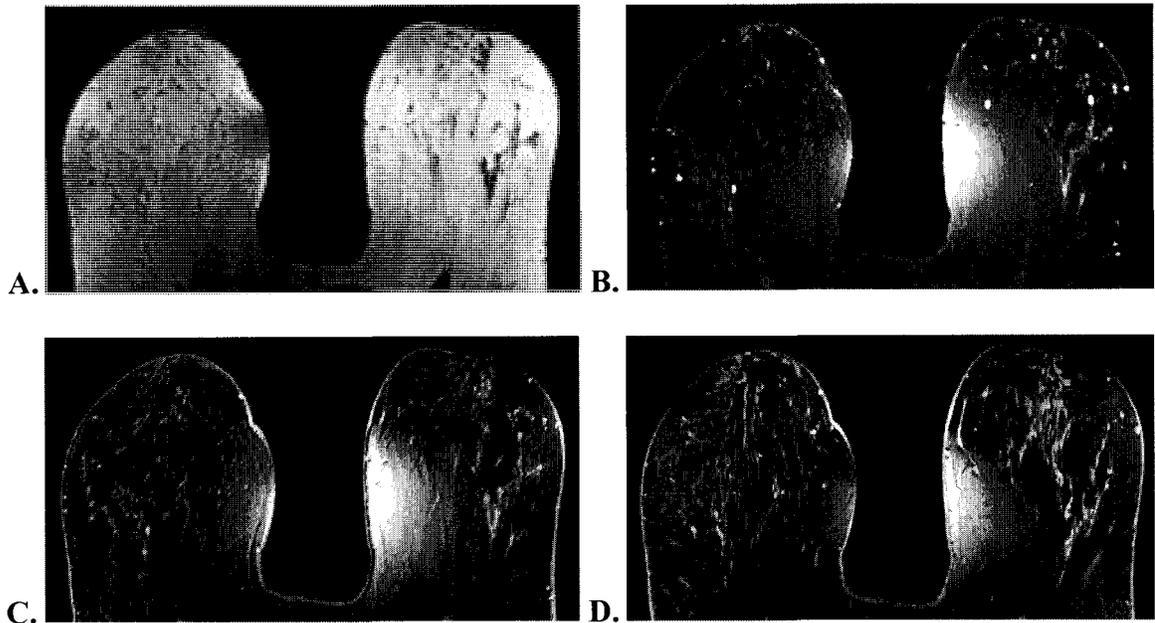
Patient 2 images from each scan performed. A) is slice 34 from the T1-weighted scan. B) is slice 34 from the T2 SPAIR scan. C) is slice 405 from the Dynamic Thrive scan. D) is slice 95 from the Thrive Post scan.
